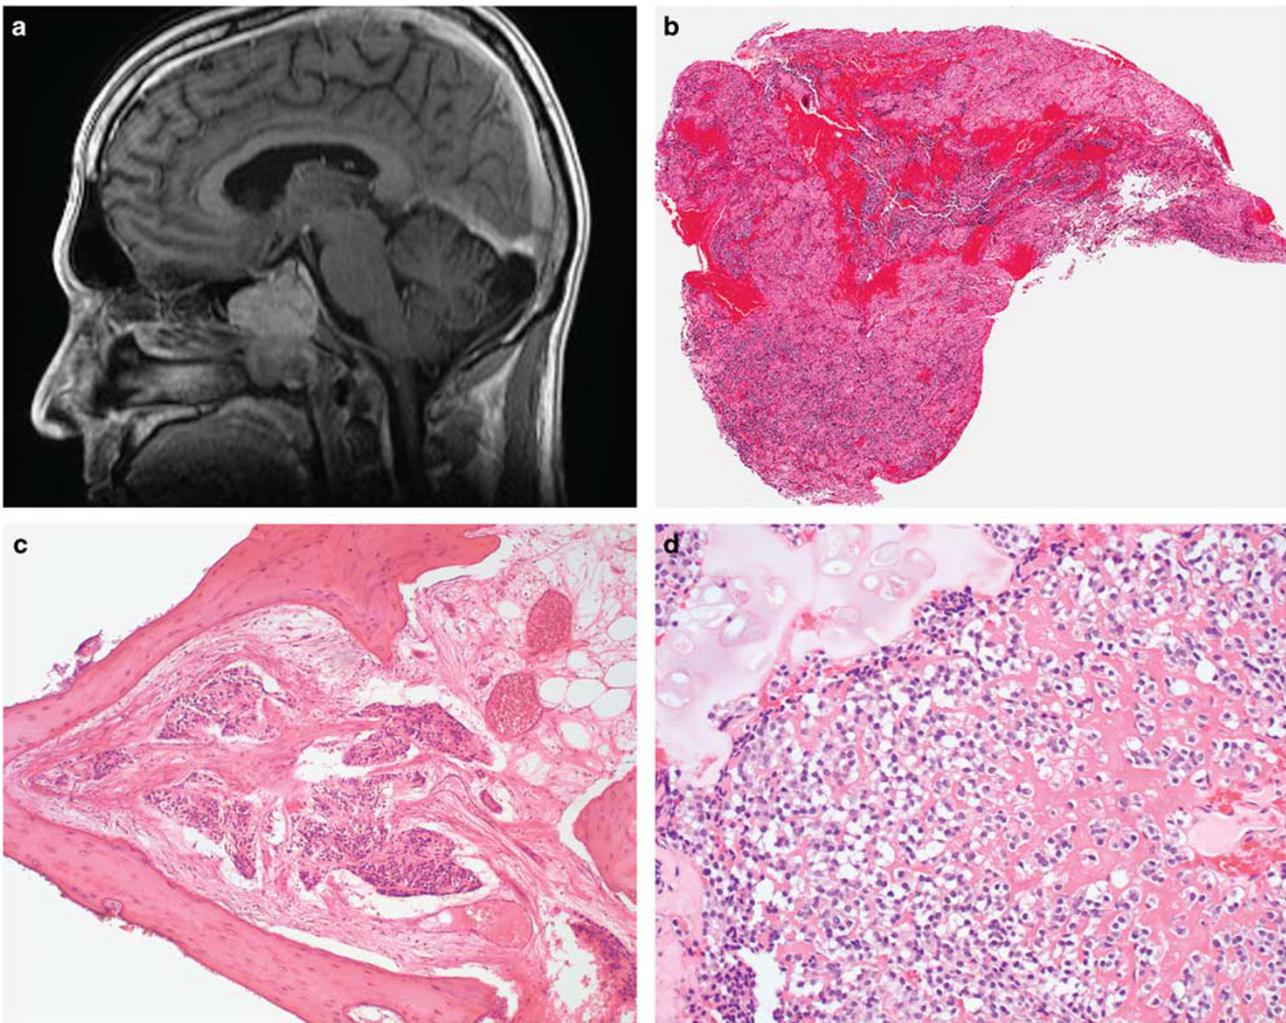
Pituitary adenoma. This sagittal MRI shows a large mass within the pituitary sella and expanding into the sphenoid sinus (a). The tumors often appear polypoid (b). Bone invasion (c) may be seen, while cartilage invasion (d) may also be present. This is not neoplastic cartilage or bone, but destruction of the native structures.
